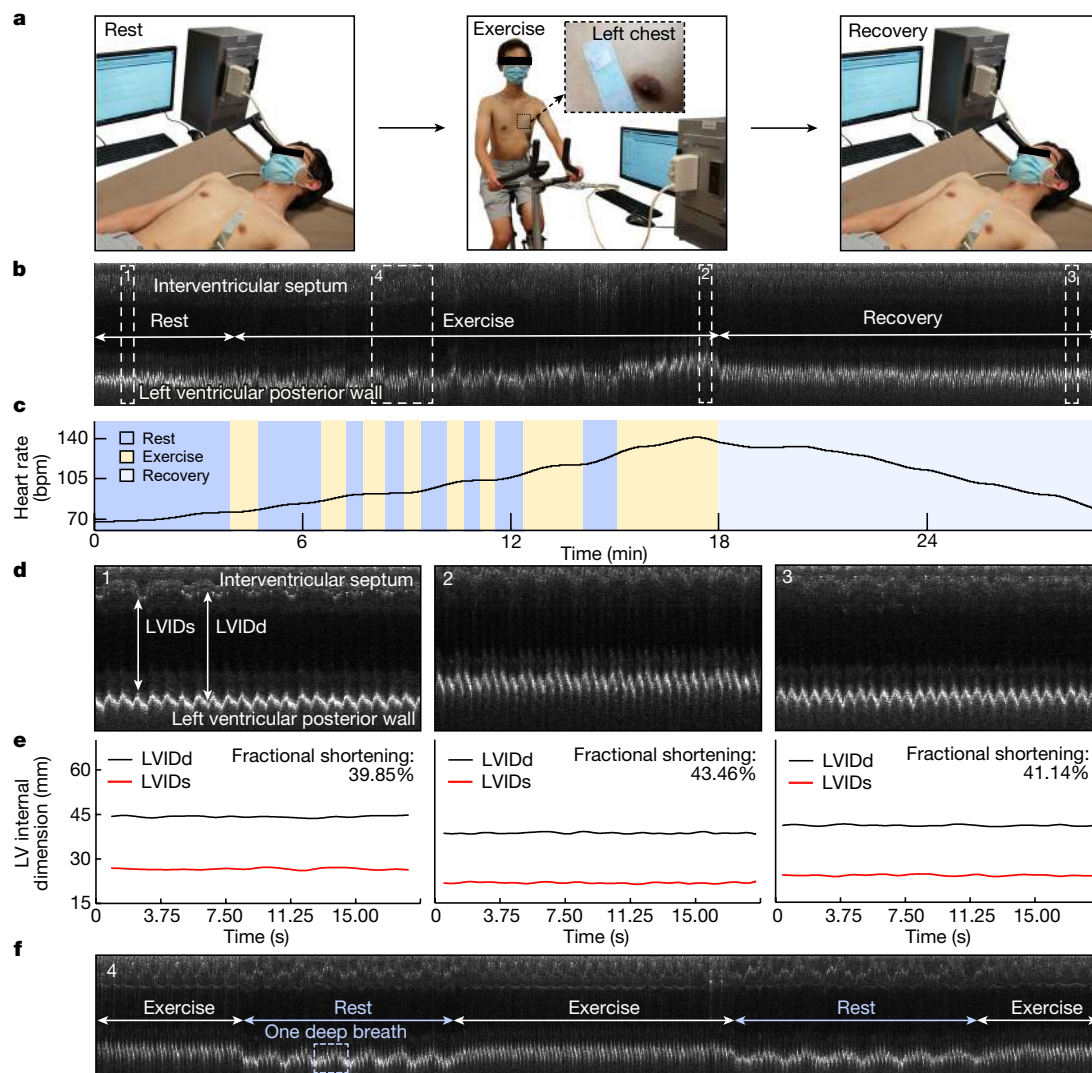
Monitoring during motion. a, Three stages of stress echocardiography. In the rest stage, the subject laid supine for around 4 min. In the exercise stage, the subject rode a stationary bike for about 15 min, with intervals for rest. In the recovery stage, the subject laid supine again for about 10 min. The wearable imager was attached to the chest of the subject throughout the entire test, even during the transitions between the stages. b, Continuous M-mode echocardiography extracted from the parasternal long-axis-view B-mode images of the entire process. Key features of the interventricular septum and left ventricular posterior wall are identified. The stages of rest, exercise (with intervals of rest) and recovery are labelled. c, Variations in the heart rate
